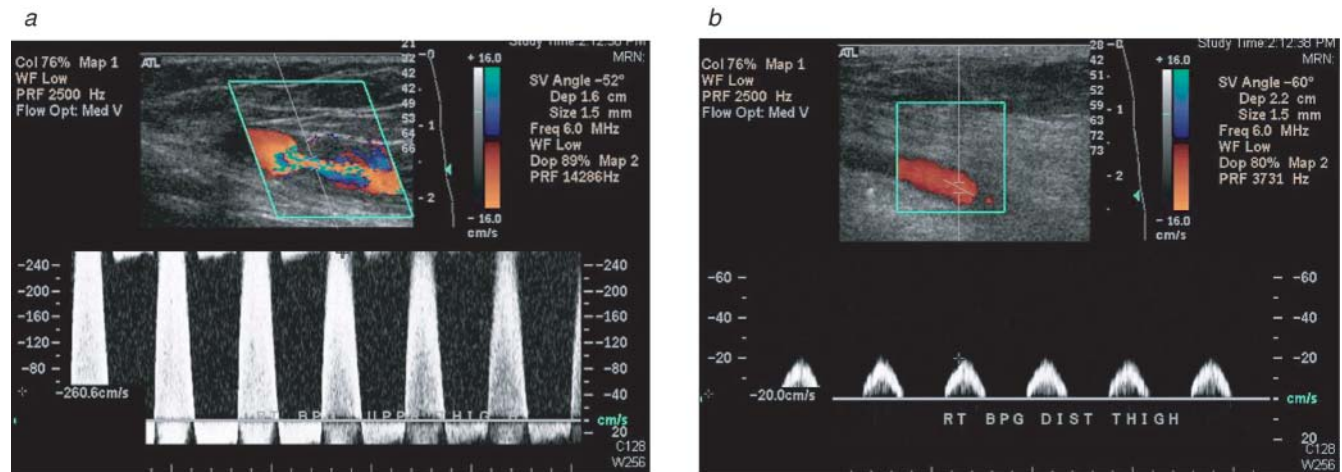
A 68-year-old female presented with two-block intermittent claudication, no rest pain, and no ulceration. A right femoropopliteal vein bypass was created 6 years previously. (a) A duplex sonogram of the vein bypass demonstrates a tight stenosis within the midvein bypass with markedly elevated peak systolic velocity (PSV) of 260 cm/s. (b) A duplex sonogram of the vein bypass distal to the stenosis demonstrates patency but a dampened waveform with a PSV of 20 cm/s.
